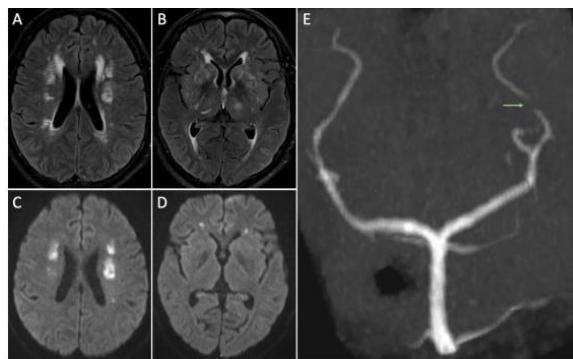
(A,B) Axial FLAIR sequence depicts multiple hyperintense lesions involving the deep and subcortical white matter on both hemispheres, as well as the thalamus and basal ganglia; some of the lesions showed restricted diffusion on DWI (C,D), namely on both corona radiata and bilateral deep frontal white matter. (E) 3D TOF sequence, MIP reconstruction on coronal view reveals prominent irregularity (arrow) on the P3 segment of the left posterior cerebral artery.
